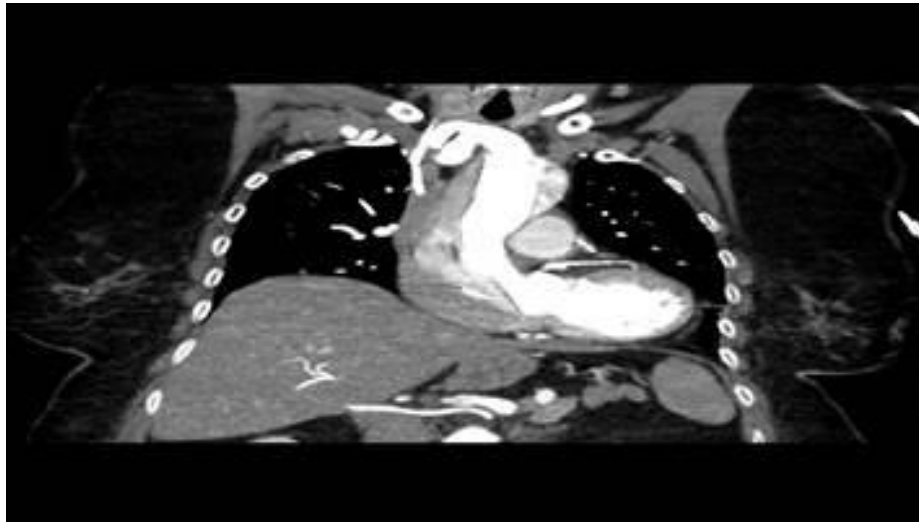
Chest CT Angiography, Coronal View showed a Type A aortic dissection within an aneurysmally dilated aorta.
